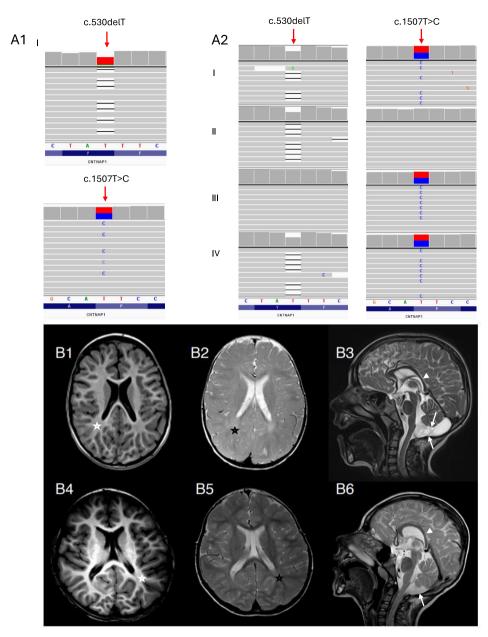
(Part A) Results of molecular genetic testing. (A1) results of exome sequencing; (A2) results of amplicon deep sequencing in the index case (P1), his parents and brother (P2) (I –P1, II-mother, III- father, IV –P2). Arrows indicate the c.530delT and c.1507T>C positions in *CNTNAP1*. (Part B) Patient P1 presenting decreased signal on T1-weighted images in "terminal zone" at the level of the peritrigonal area (B1) and increased signal on T2-weighted images (B2). In the sagittal plane, enlarged cisterna magna and hypoplastic posterior part of the body of the corpus callosum are present (B3). Patient P2 presenting mildly decreased signal on T1-weighted images in "terminal zone" at the level of the peritrigonal area (B4) and increased signal on T2-weighted images (B5). In the sagittal plane, moderately enlarged cisterna magna and hypoplastic posterior part of the corpus callosum are present (B6).
